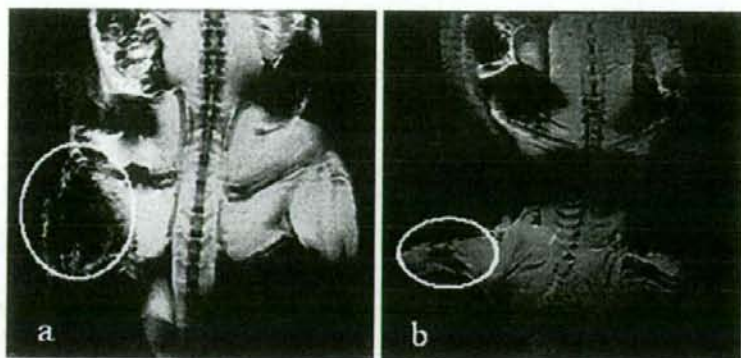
T₂*-weighted MRI of right thigh after femoral injection of SPION-alginate with 0.5 h exposure time to magnetic field (A) or not (B). The images were taken at 10 h after injection, which still showed accumulation of iron oxide in target site with the magnetic field, since the strong signal intensity decreased (white circle in A). But the iron oxide did not accumulate in target site (white circle in B), which could be attributed to the slight change of signal intensity without the magnetic field.
